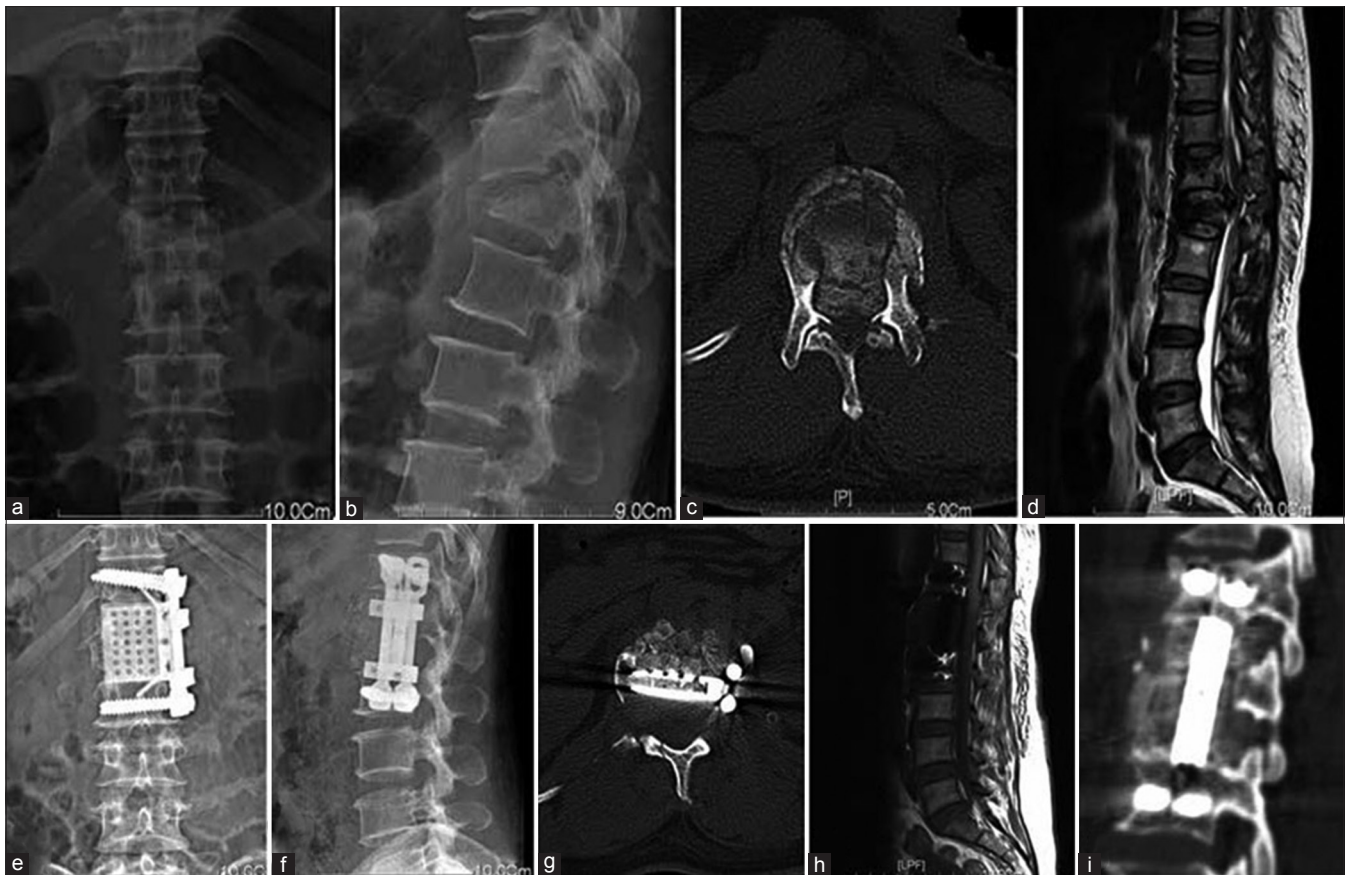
X-ray of dorsolumbar spine anteroposterior (a) and lateral (b) views showing an L1 burst fracture and kyphosis (c) Axial CT scan showing retropulsed fragment of L1 burst fracture (d) T2W mid sagittal MRI of dorsolumbar spine showing L1 burst fracture and spinal canal compression (e and f) X-ray anteroposterior and lateral views showing cage and implant *in situ* (g) Axial CT scan showing decompression and implant *in situ* (h) T1W mid sagittal MRI showing decompression (i) Reconstructed CT image at burst level showing adjacent vertebral bodies, cage and implant
